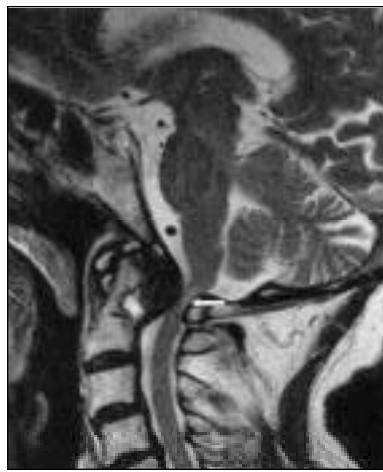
The mass has low signal intensity on TSE T2-weighted sagittal MRI and the compressed cord shows hyperintensity (white arrow) suggestive of edema/myelomalacia.
